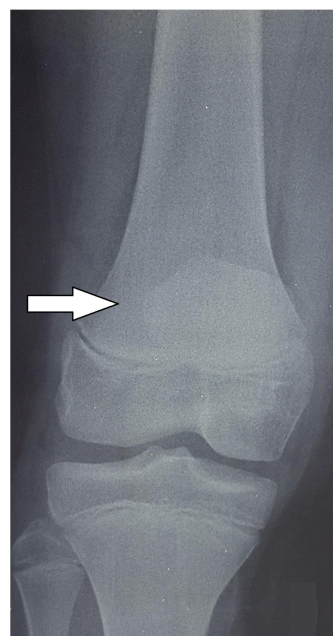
A. High riding patella (AP left knee radiograph) and B. High riding patella with avulsion tibial tubercle fracture (white arrow) (lateral left knee radiograph)
